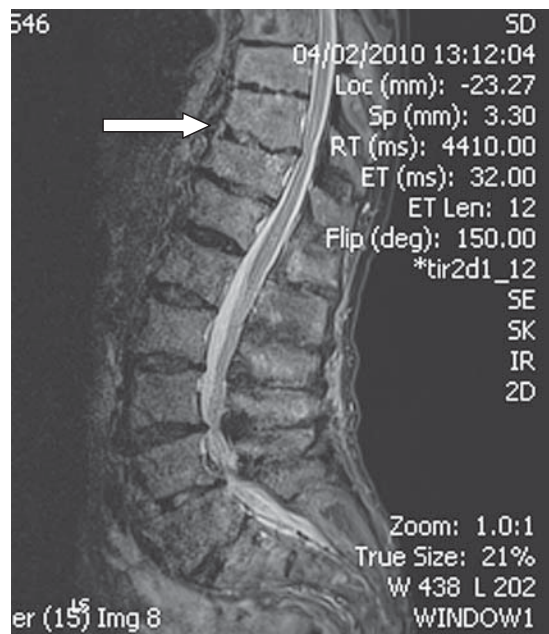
MRI spine with spinal cord compression (arrow) and multi-level degeneration.
